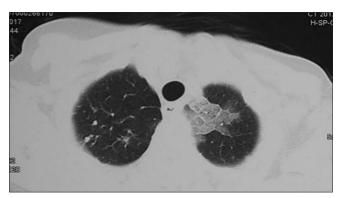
Computed tomography (lung window) demonstrating a lesion in the left upper lobe and post left mastectomy status
